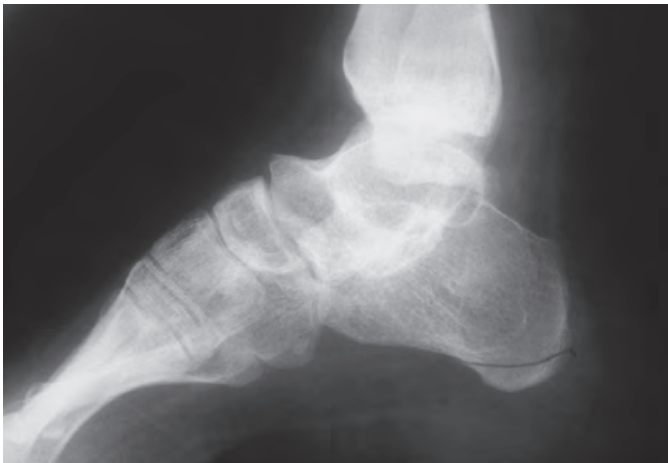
Lateral radiograph of left foot after triple arthrodesis. Note the supinated position of the foot.
